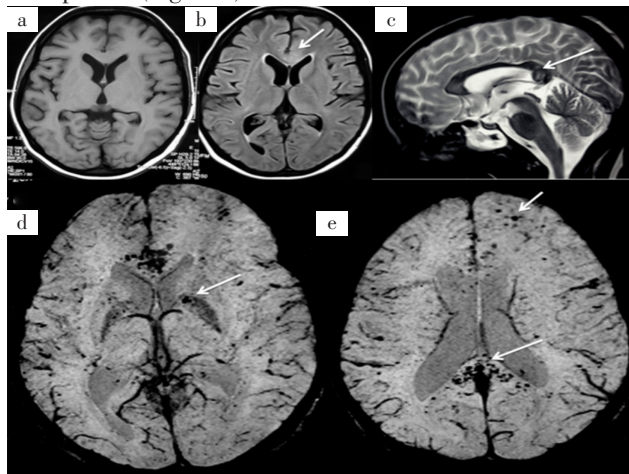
MRI and SWI of the brain of the patient.
